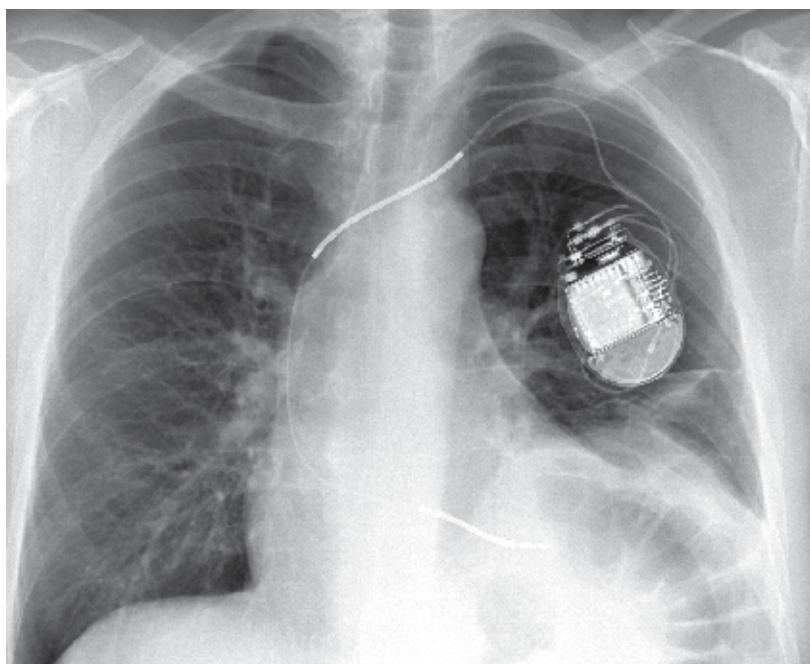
Chest X-ray showing a ventricular lead that is located higher than usual; this lead is in the left ventricle, having gone through a patent foramen ovale.
